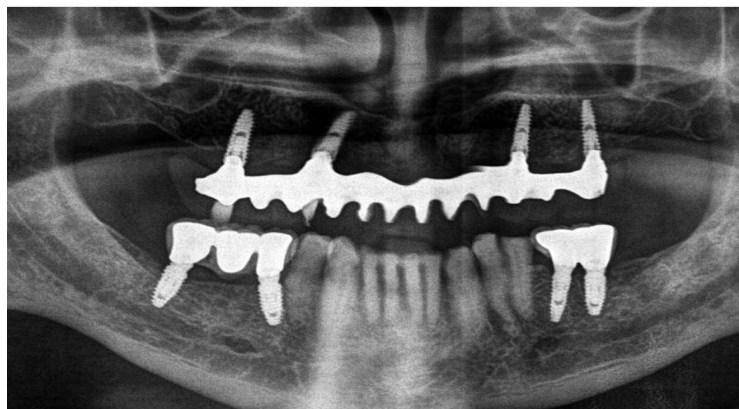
Postoperative orthopantomograph
